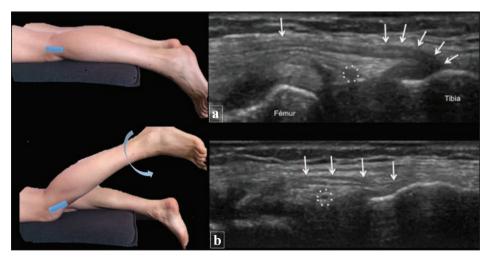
Ultrasound of the ALL. Study of the ligament (arrows) with a very high frequency 15 MHz superficial transducer. Ligament in resting position (figure a), relaxed at its tibial enthesis. Dynamic flexion and internal rotation maneuver (figure b) making the ligament tense so that it straightens.
